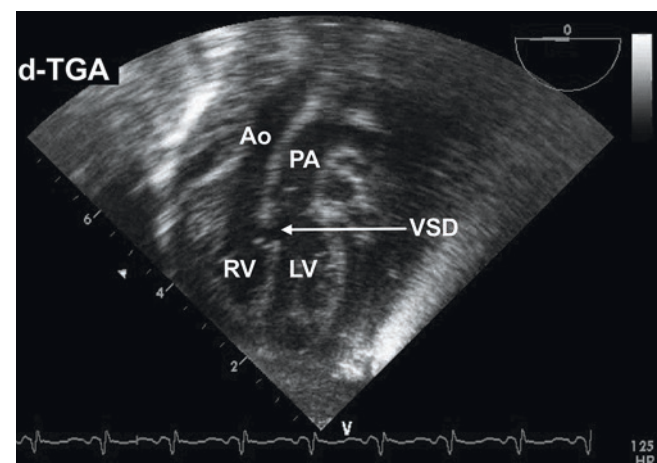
Preoperative deep-transgastric transesophageal echocardiogram in a neonate with *d*-transposition of the great arteries (*d*-TGA) and a ventricular septal defect (VSD) undergoing complete repair. *Ao* aorta, *LV* left ventricle, *PA* pulmonary artery, *RV* right ventricle
